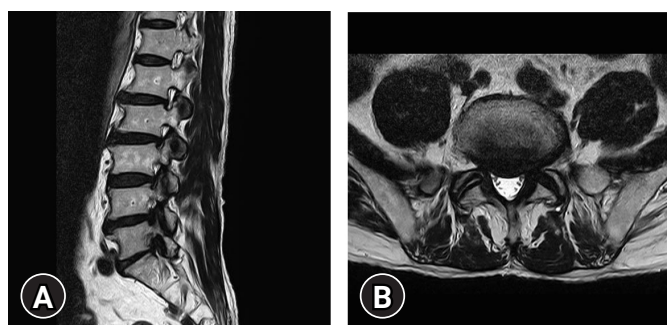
(A) Sagittal T2-weighted magnetic resonance image (MRI) showing left severe foraminal stenosis at L5-S1 level. (B) Axial T2-weighted MRI showing central disc protrusion at L5-S1 level.
